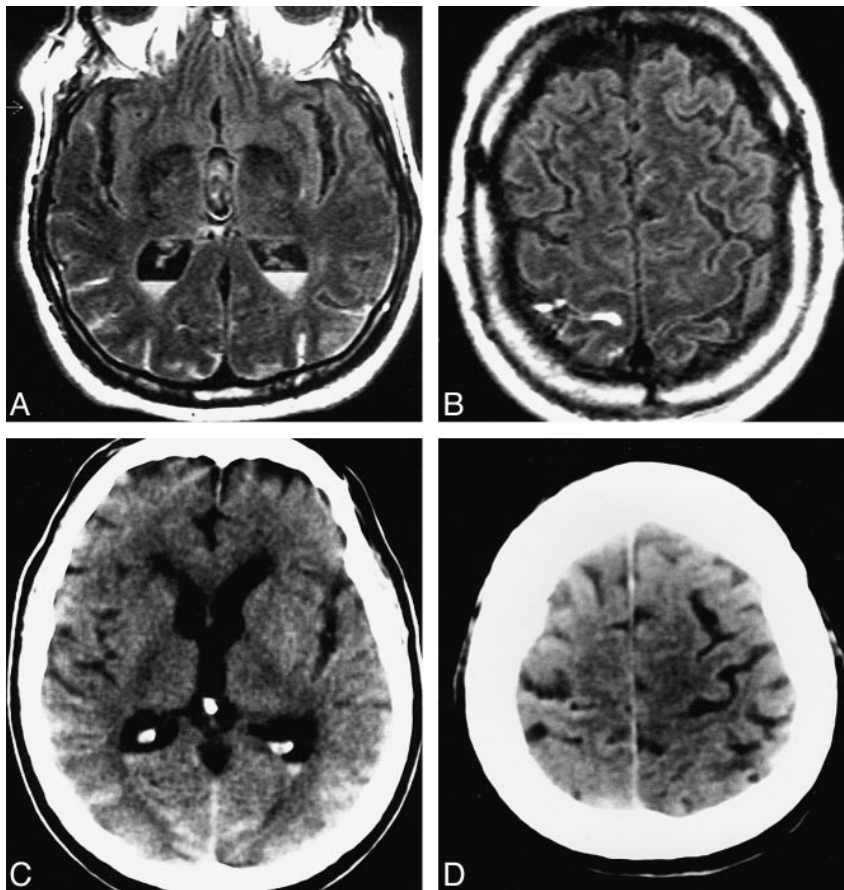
Case 12: 70-year-old man with subacute aneurysmal IVH and SAH who had MR imaging 9 days after ictus and CT 8 days after ictus. The FLAIR images show each occurrence of hemorrhage more conspicuously than do the CT scans. Although both FLAIR MR imaging and CT depicted IVH, the FLAIR images more crisply show the fluid-fluid levels characteristic of IVH.
